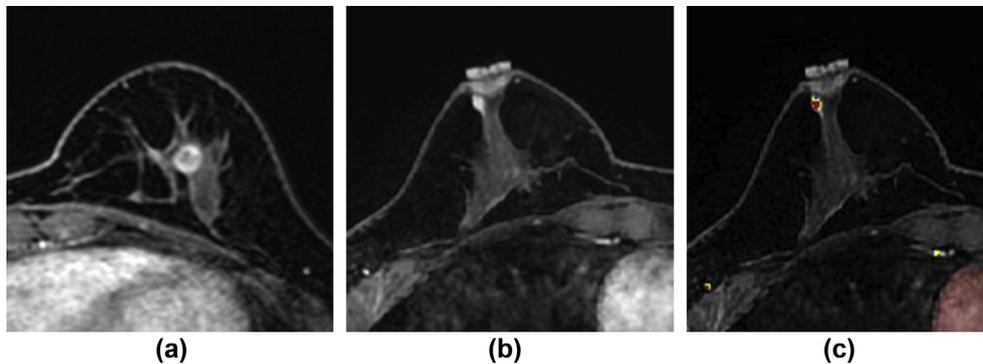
Screening breast MR images of 40-year-old woman with personal history of contralateral breast cancer. (a) The patient underwent left breast conserving surgery for newly diagnosed breast cancer in left breast 4 o'clock direction. (b) After 1 year, early contrast-enhanced axial image shows 0.5 cm oval enhancing lesion in right breast subareolar (arrow). Reader 1 interpreted this lesion as category 4a and reader 2 as category 3. (c) On the same image with CAD, lesion shows delayed washout enhancement pattern. Reader 1 changed the diagnosis as category 4b and reader 2 as category 4a. US-guided core needle biopsy was performed and the pathologic result was fibrocystic change. This case is an example of false positive with the addition of CAD system.
